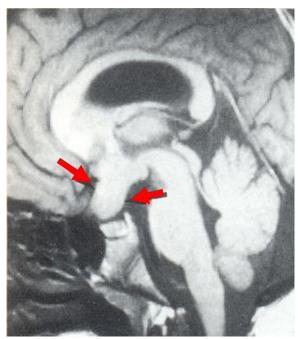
MR in a 5yr old with NF1-Glioma of the optic nerves & chiasm (large arrows). Bright image in T2 weighted MRI.
